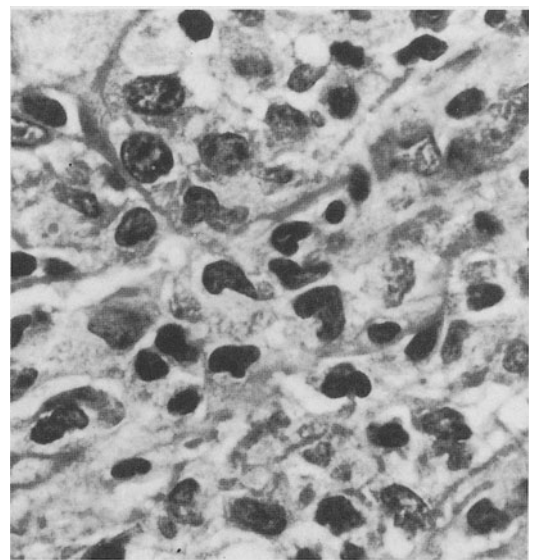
Mixed-cell lymphoma presenting as diffuse radiograph infiltrates. The process surrounds airways and vessels and infiltrates the vessels. The mixed-cell population suggests
